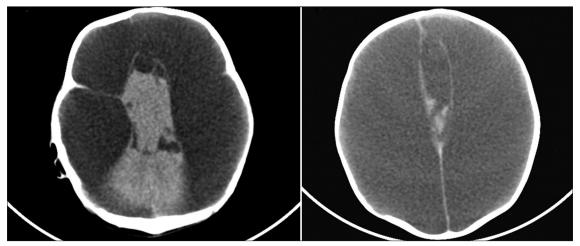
Non-contrast axial CT image shows (a) complete destruction of bilateral cerebral hemispheres with no evidence of cortical mantle with preserved midbrain and (b)falx cerebri
